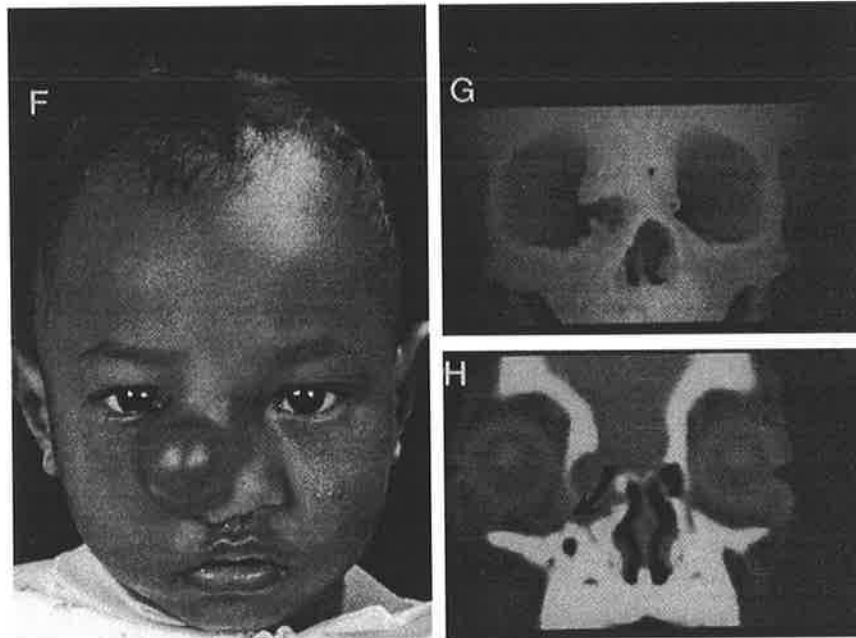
(cont.). F—H, a nasoorbital type of frontoethmoidal meningoencephalocele. The defect in the right medial orbital wall is demonstrated with the three-dimensional CT reconstruction. The coronal section shows the encephalocele's path into the right orbit.
